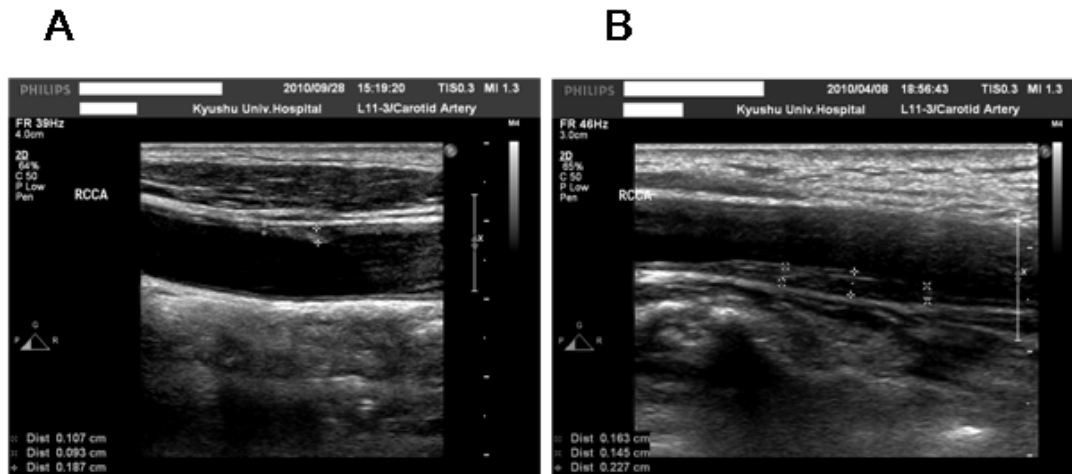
Two representative carotid ultrasound imaging
